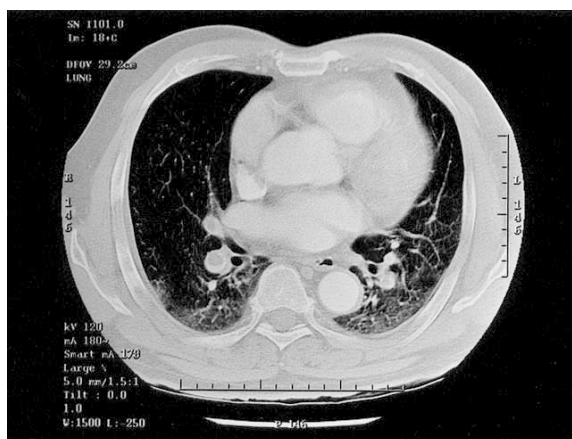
Spiral CT Scan showing filling defects in the segmental branches of the pulmonary arteries in both sides. Note the clear relationship of the bronchioles to the arteries.
